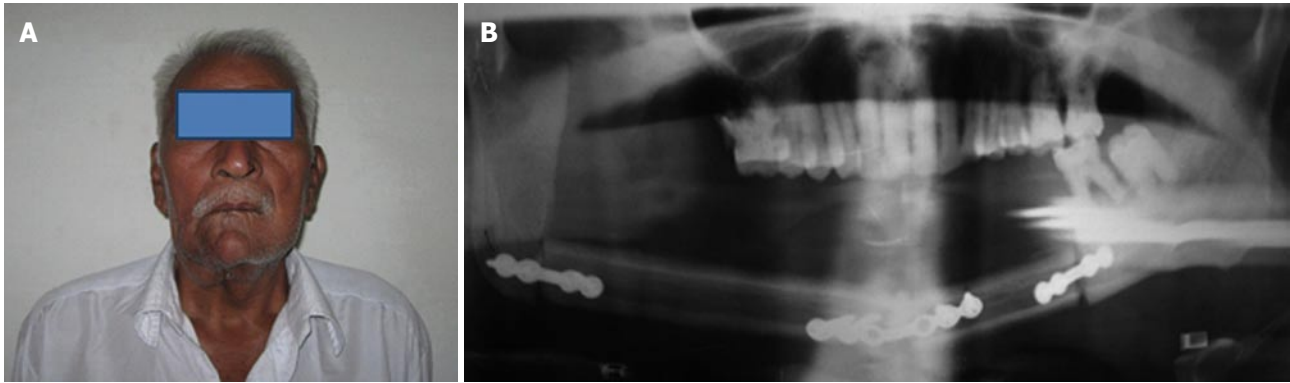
Post-op photograph (A) and orthopantomograph (B) of patient after surgical resection of the tumor by microvascular reconstructive surgery and reconstruction with a fibula graft.
